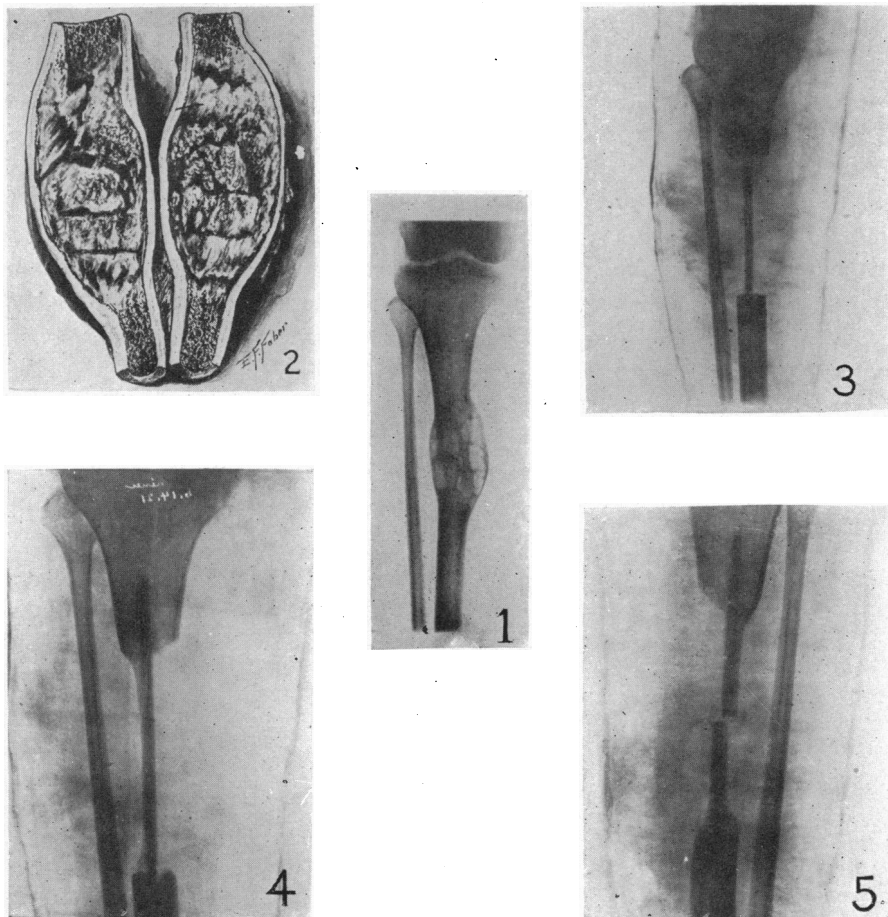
X-ray appearance of cyst.
